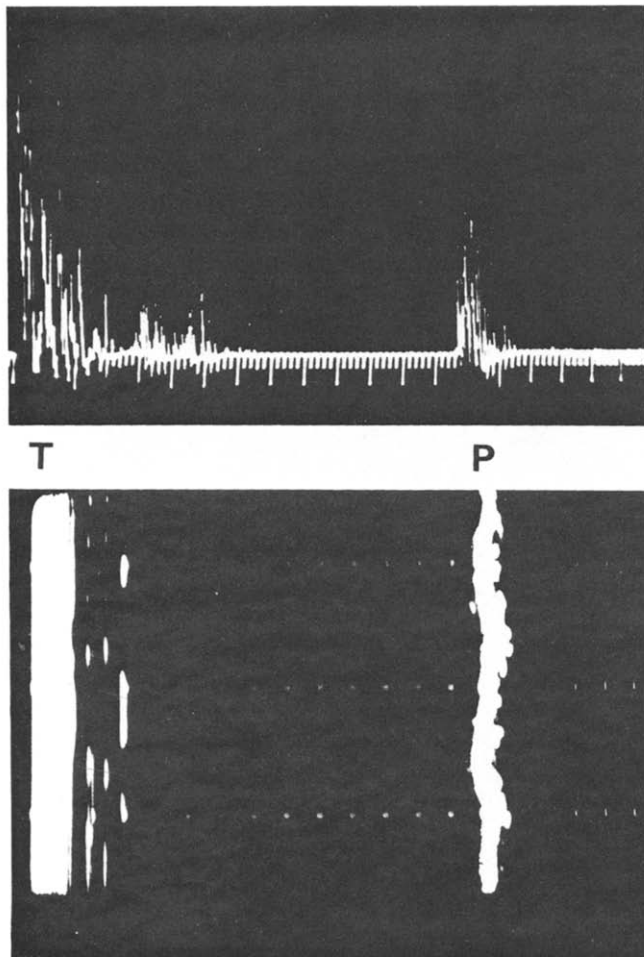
Echocardiograms taken in the early 1960s of a patient with pericardial effusion. AW = anterior wall; P = pericardium; PW = posterior wall; T = transducer. (Reprinted from Feigenbaum H, Zaky A, Waldhausen JA [15], with permission.)
